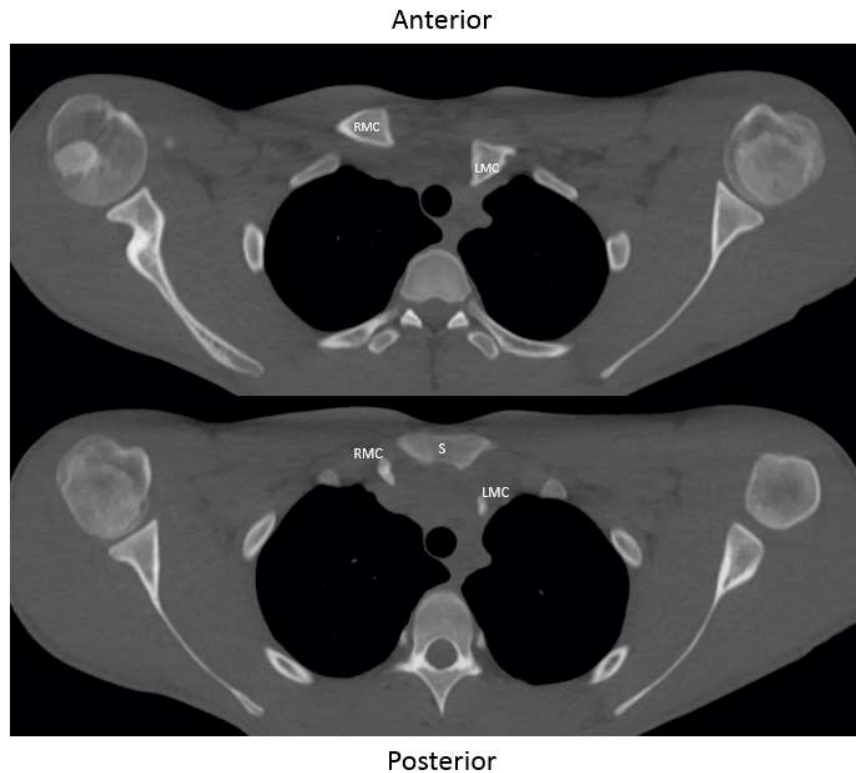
Consecutive axial CT scan images of the chest demonstrating posterior displacement of the left medial clavicle relative to the sternum (S=Sternum, RMC=Right medial clavicle, LMC= Left medial clavicle).
